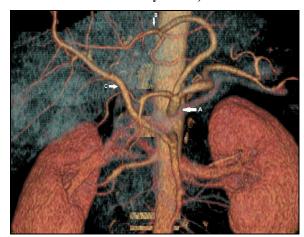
A 3D reconstructed image from CT angiogram of a 56-year-old male showing gastrosplenic trunk (Uflacker type-V; arrow A)
